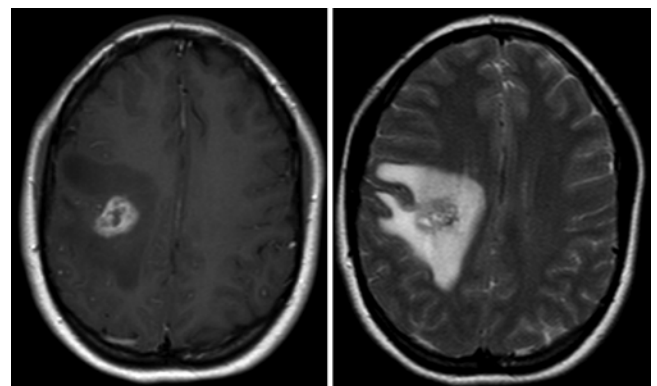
Axial MR images obtained 9 months after GKS at the time of the patient's initial presentation to the emergency department. A T1-weighted postcontrast image (left) demonstrating enhancement in the area of the AVM with surrounding hypointensity and a T2-weighted image (right) demonstrating T2 hyperintensity correlating with T1 hypointensity consistent with edema.
